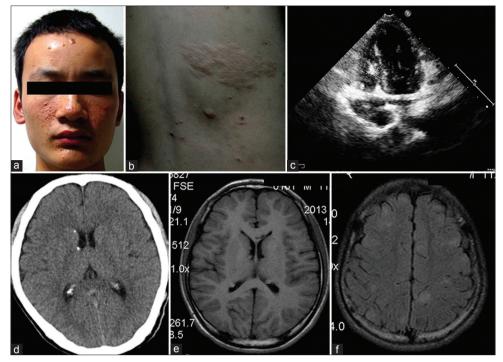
(a) Forehead fibrous plaque and facial angiofibromas of the proband. (b) Shagreen patches on the back of the proband. (c) Heart ultrasound of the younger brother detects multiple cardiac rhabdomyoma. (d) Brain computed tomography of the father shows multiple subependymal calcifications. (e) Brain magnetic resonance imaging (MRI) of the proband reveals subependymal nodules along the lateral walls of the lateral ventricles. (f) Brain MRI of the proband demonstrates multiple cortical tubers.
